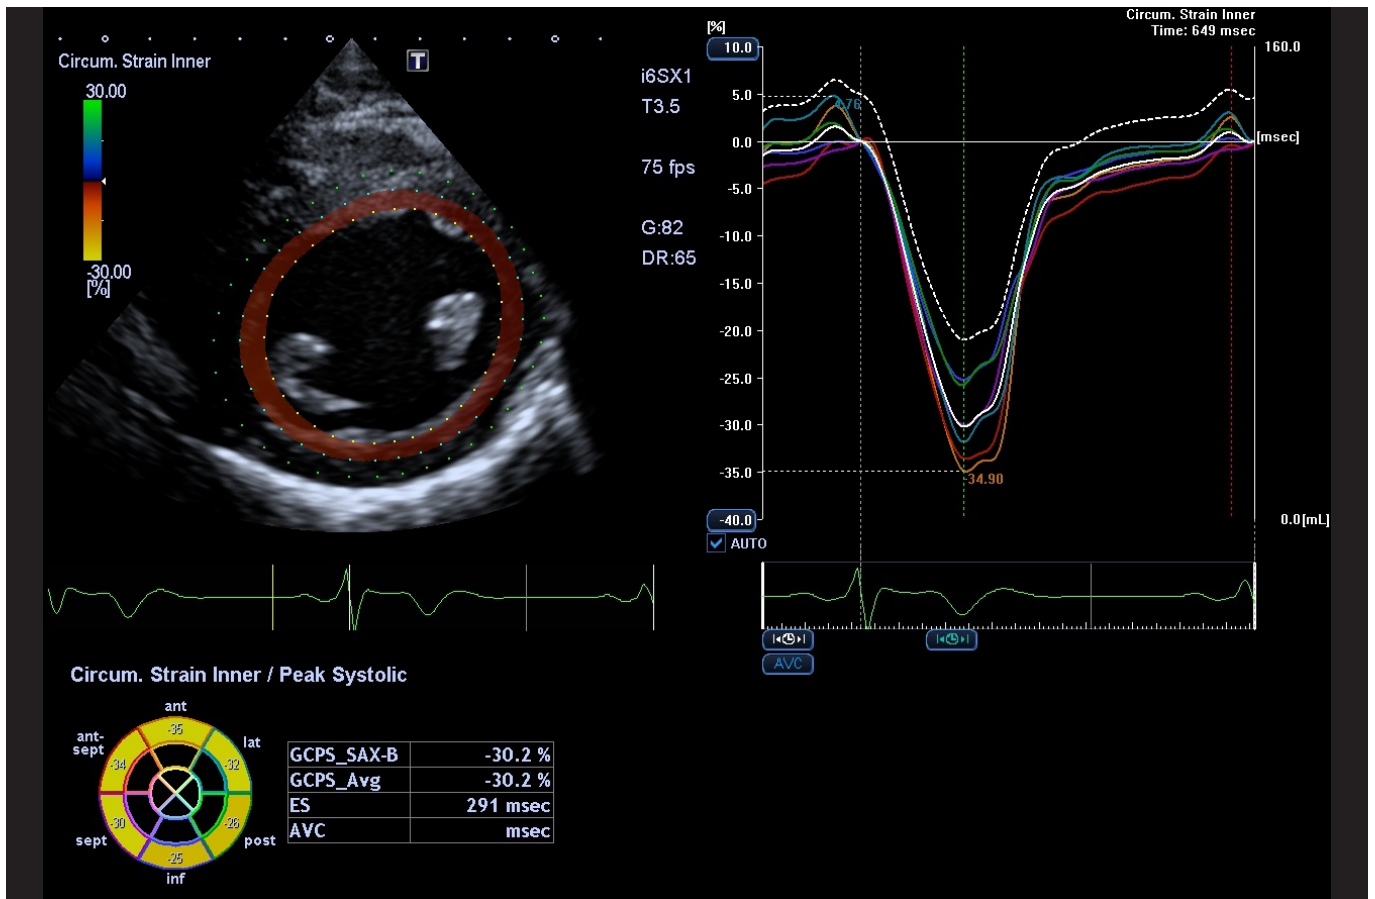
Resting LV circumferential strain analysis of short axis base view using Vitrea for ultrasound (V7.11) software.
